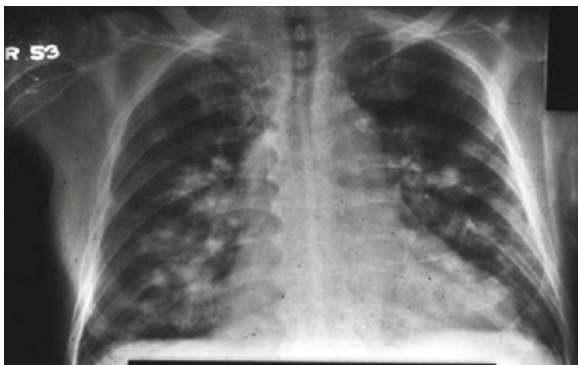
Chest X-ray showing bilateral patchy infiltrates in a neutropenic patient with invasive fusariosis
